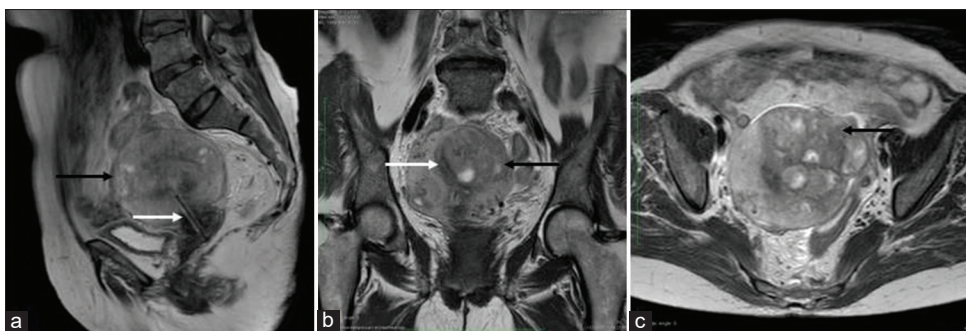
(a) T2-weighted sagittal, (b) coronal, and (c) axial magnetic resonance imaging images of pelvis showing a bulky enlarged uterus with multiple intramural lesions (black arrows) and serosal surface irregularity. Note a sharply delineated T2 hypointense line (white arrows) in the uterocervical region representing the intrauterine device.
